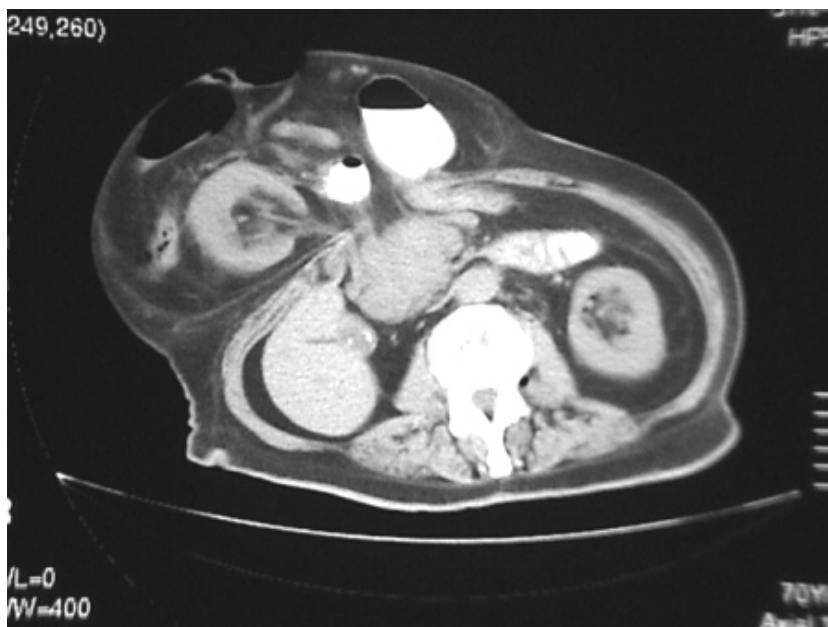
CT scan of an incisional hernia
